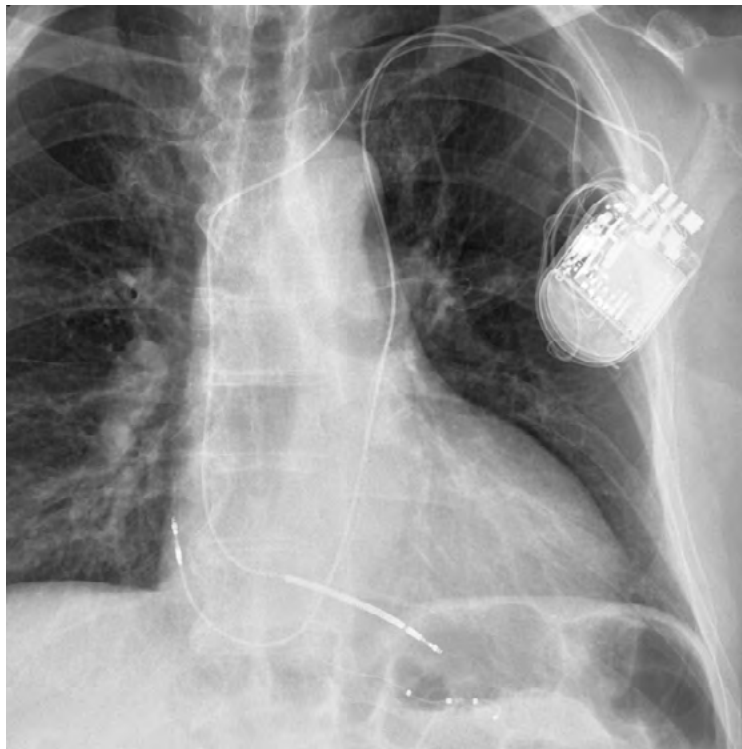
X-ray after procedure showing the proper location of leads
